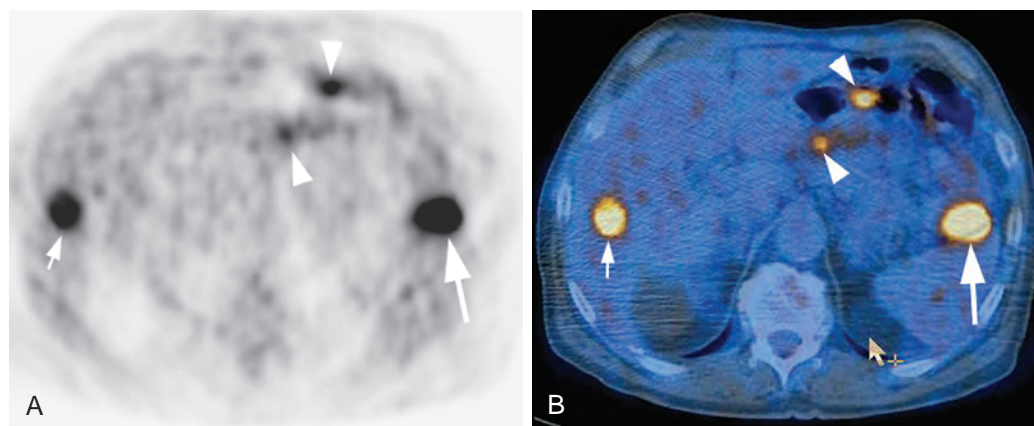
PET for staging in patient with history of splenic flexure carcinoma. A. Axial FDG-PET image demonstrates increased FDG uptake in anticipated location of splenic flexure (*large arrow*) and in liver (*small arrow*). Two additional areas of increased FDG uptake (*arrowheads*) are seen in expected location of hepatic flexure. B. The fused PET/CT scan shows that left flank activity is located in the splenic flexure primary tumor (*large arrow*), and a large area of increased activity on the right corresponds to hepatic lesion (*small arrow*) seen on CT. Two small areas of increased activity (*arrowheads*) were not seen on CT and represent small implants on surface of hepatic flexure. Although CT detected both primary tumor in splenic flexure and hepatic metastasis, serosal colonic implants were missed.
